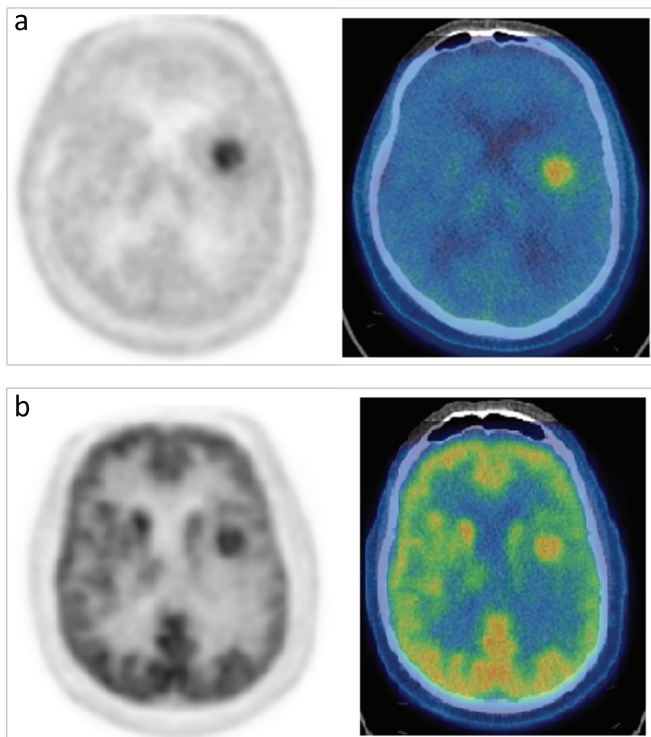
High-grade glioma: (a) Transaxial brain scan shows increased ^{11}C -methionine in a left frontal lobe lesion; (b) ^{18}F -FDG PET/CT shows increased metabolic activity at the same site indicating a high-grade tumour.
